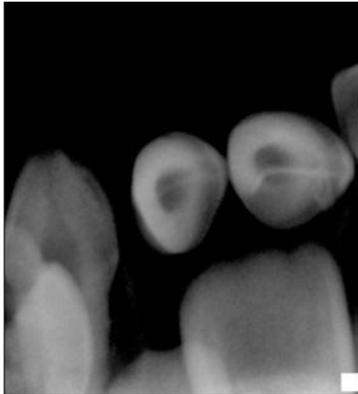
Intra-oral periapical radiograph after the injury.
